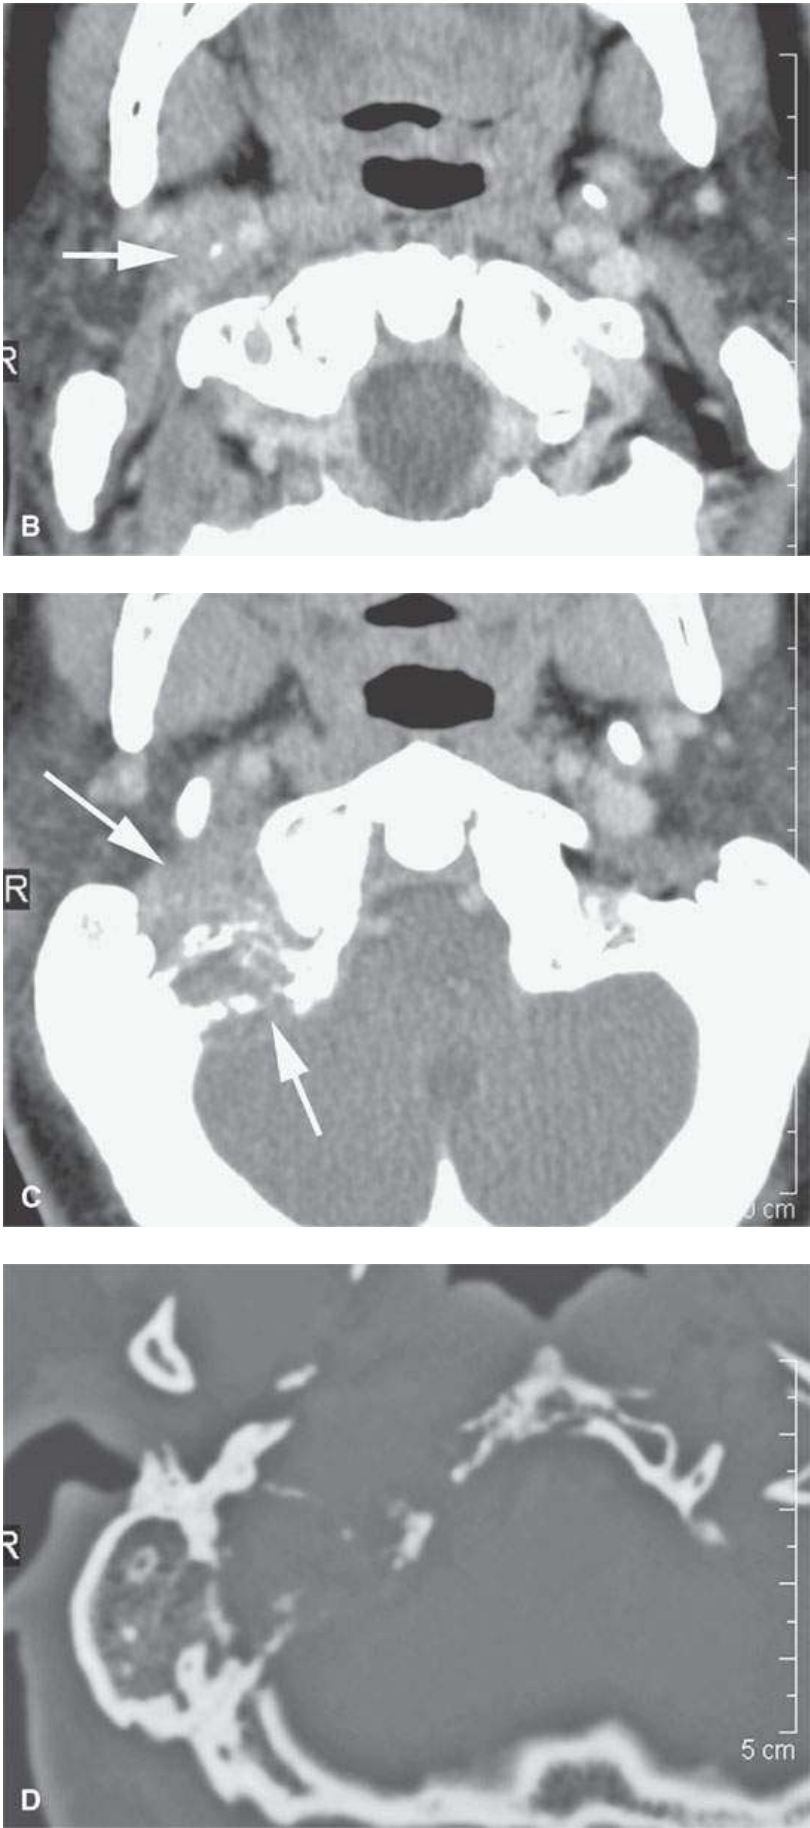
Contrast-enhanced computed tomography in a patient thought to have a just localized superficial failure in the skin of the neck at the original site of the squamous cell skin carcinoma; however, the patient had worsening right suboccipital headaches and otalgia. Deeply recurrent tumor tracks along the carotid sheath in the retrostyloid parapharyngeal space (*arrows*) are seen in (A) through (C) to eventually invade the skull base (D).
